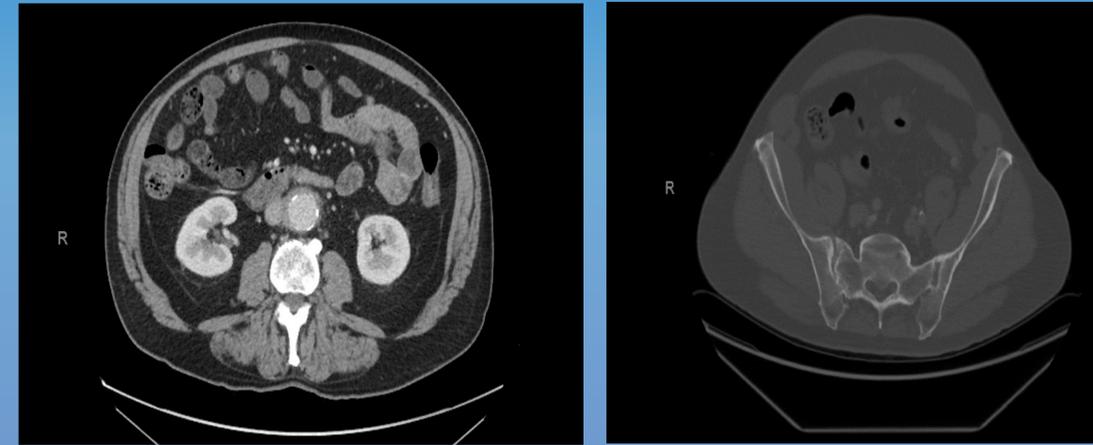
Aortitis and bilateral sacroiliitis on CT imaging
